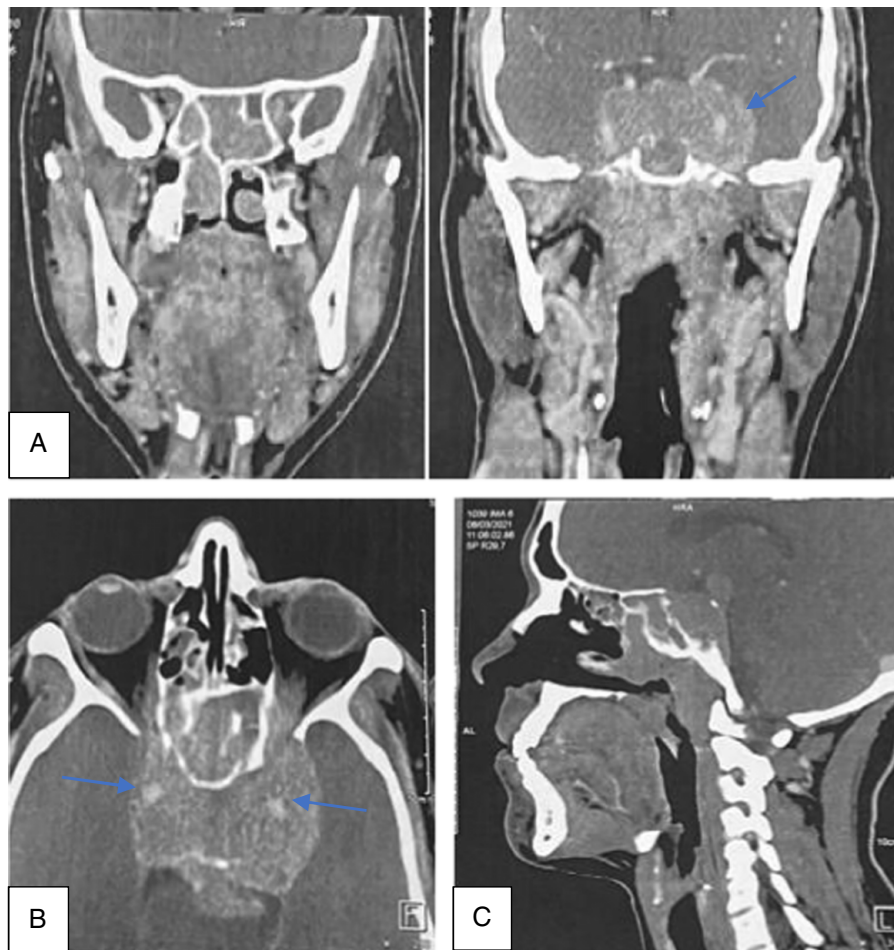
Enhanced computed tomography scan of the skull base and paranasal sinuses; coronal (A), axial (B), and sagittal slices (C) showing mildly enhancing mass of the sphenoid sinus with intralesional calcifications (blue arrows) and bone erosion intracranial involvement and extending to the ethmoid sinuses the nasal septum to the nasal cavity.
